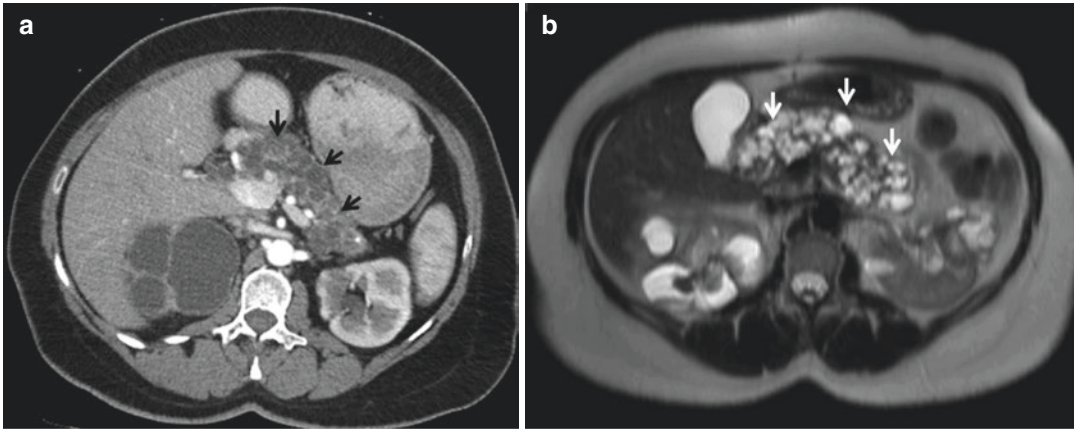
Transverse CT (a) and T2W MR (b) images of a 38 years old woman with von Hippel-Lindau syndrome. Diffuse distribution of multiple small cysts in pancreas parenchyma (arrows)
